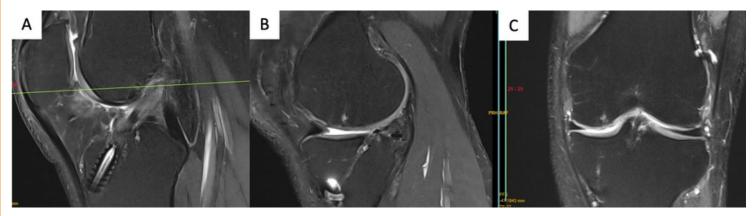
Post operative MRI. A: Well healed ACL, B&C: Well incorporated cartilage plugs & healed medial meniscus root
